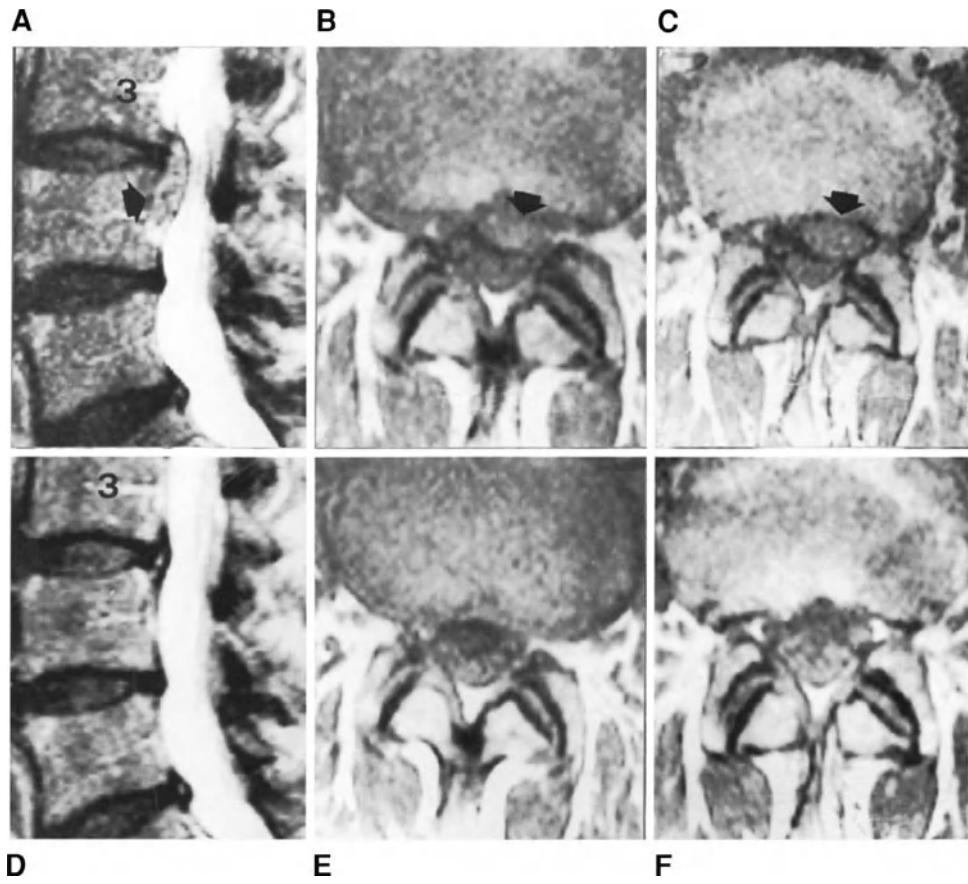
(A)–(C) Sagittal T2-weighted spin-echo MR image (A) and axial T1-weighted spin-echo (B) and (C) images at L3-L4 level in a patient with anterior thigh pain on the left. A large retroligamentous extruded herniation is visible at L3-L4 level on the left (arrows). (D)–(F) MR images obtained 5 months after the previous examination: complete disappearance of disc herniation after conservative treatment (medical and physical therapy for 4 weeks).
